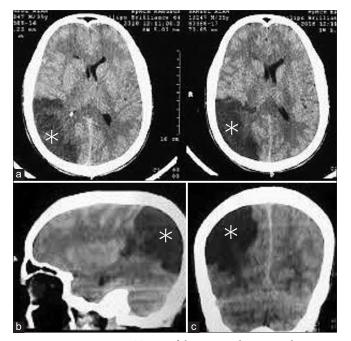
Pre-operative CT scan of the patient showing right parieto occipital infarction.
